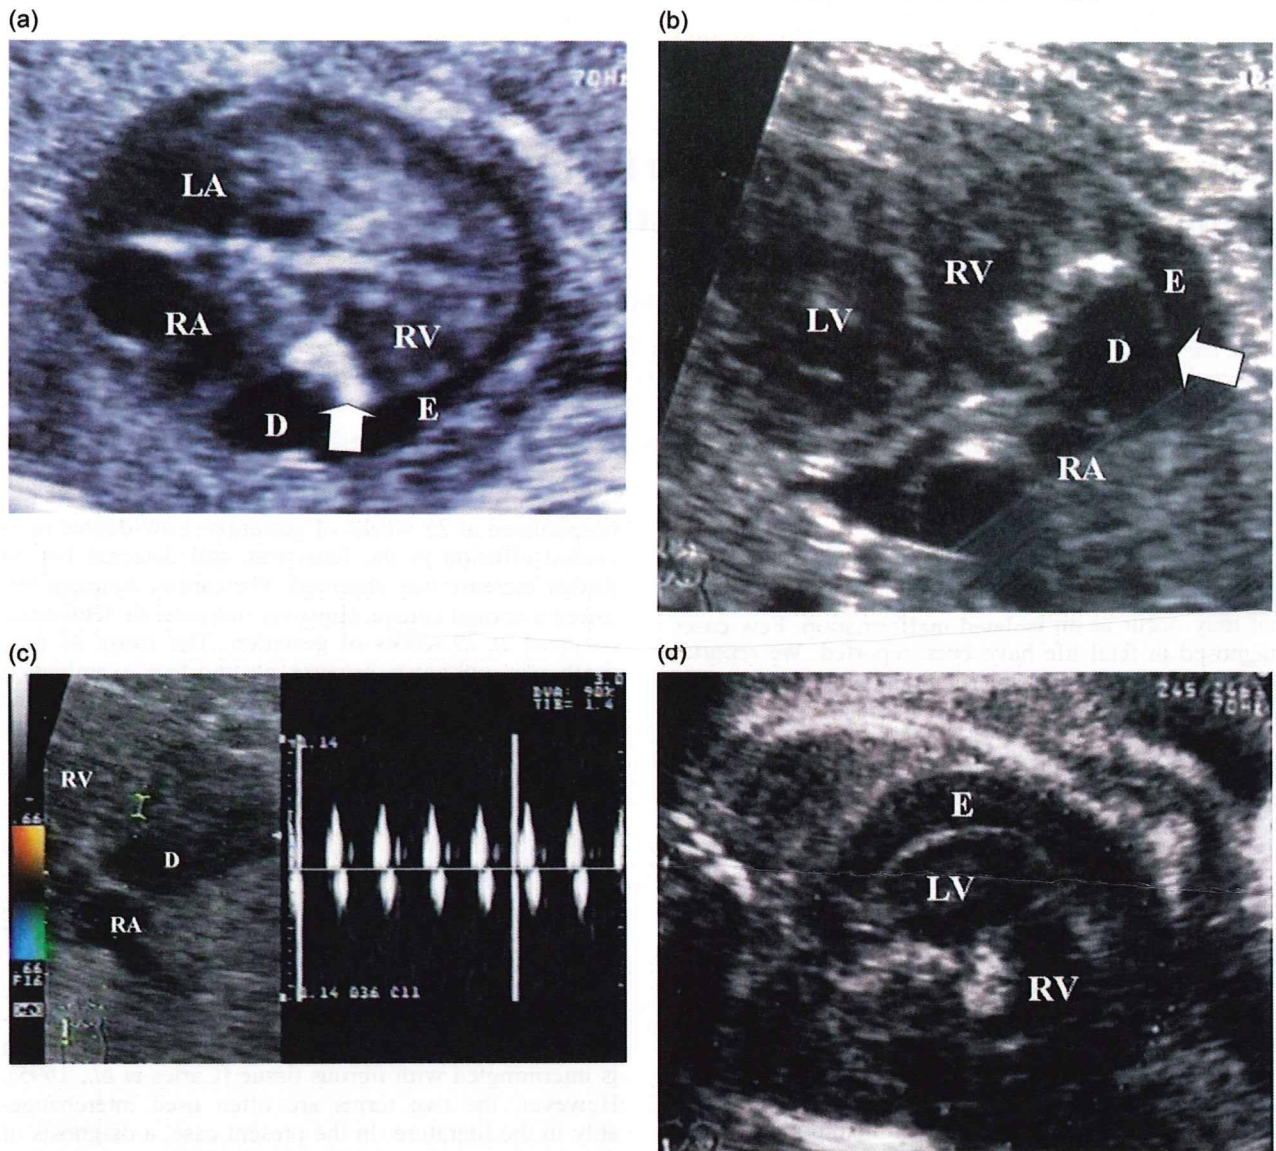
(a) Cardiac ultrasound imaging at 21 weeks of gestation. A high-echogenic focus (arrow) on the right ventricle (RV) and mild pericardial effusion (E) are depicted. LA: left atrium; LV: left ventricle; D: diverticulum; (b) Cardiac ultrasound imaging at 24 weeks of gestation. A thin-walled saccular dilatation (arrow) is identified just below the tricuspid valve. RV: right ventricle; LV: left ventricle; RA: right atrium; E: pericardial effusion; D: diverticulum; (c) Pulsed-wave Doppler imaging at 24 weeks of gestation. Bidirectional flow into and from the cardiac diverticulum is shown. RA: right atrium; RV: right ventricle; D: diverticulum; (d) Cardiac ultrasound imaging just after fetal death. Expansion of the heart and a remarkable increase in pericardial effusion (E) are depicted. RV: right ventricle; LV: left ventricle
